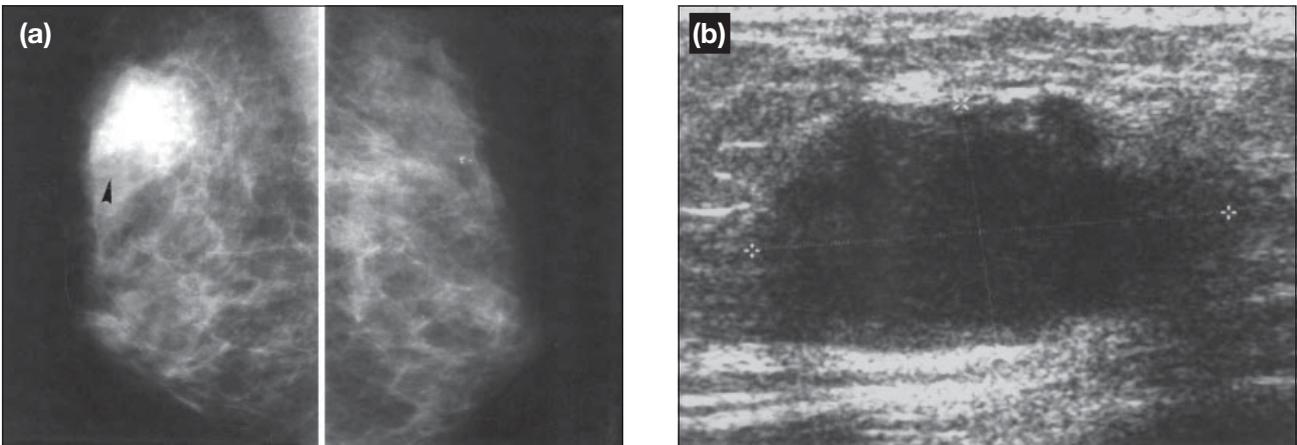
Primary lymphoma of the right breast. (a) Bilateral medio-lateral oblique views show a 2.5 cm high-density mass with ill-defined outline at the superior aspect of the right breast (large black arrowhead). (b) Ultrasound appearance of primary lymphoma shows a hypoechoic irregular mass with posterior enhancement at the superior quadrant of the right breast, suggestive of malignancy.
